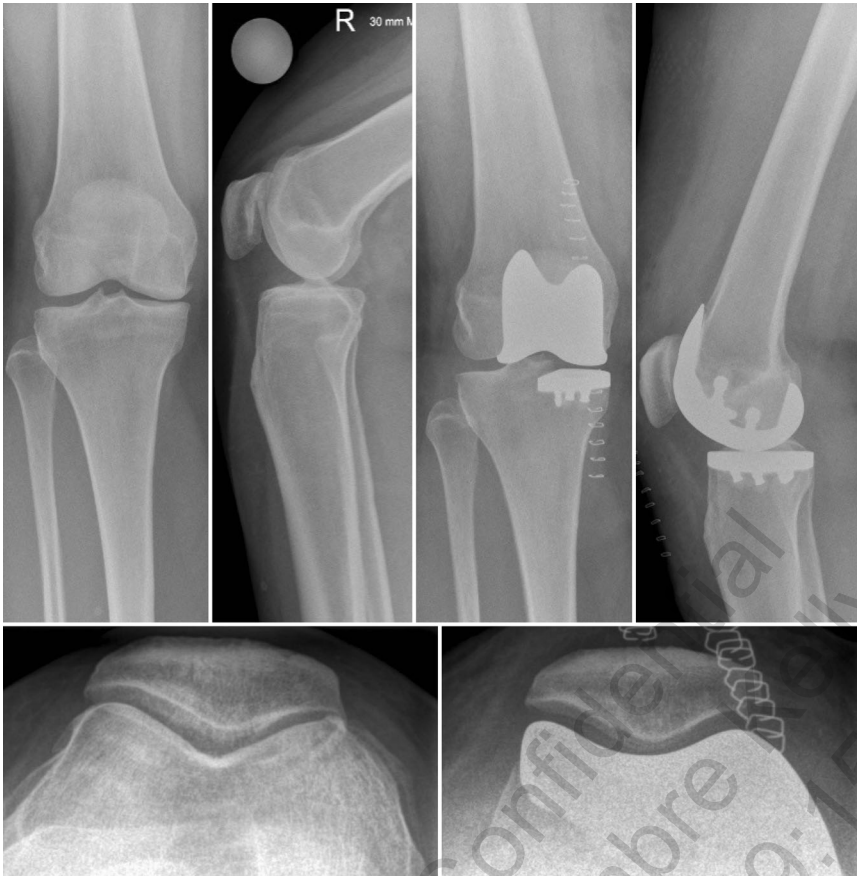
▲ Pre- and postoperative radiographic imaging of the knee joint in two planes with patella skyline view for a patient treated with a patient-specific bicompartamental implant ConforMIS iDuo G2™
